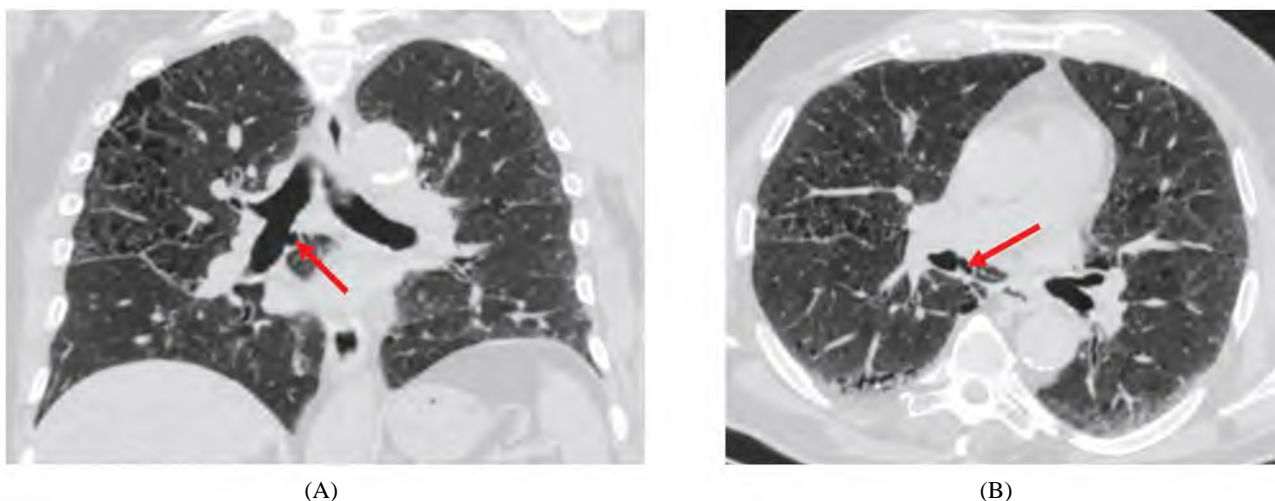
(A) Coronal (B) Axial CT images of the lung showing accessory cardiac bronchus (arrows).
